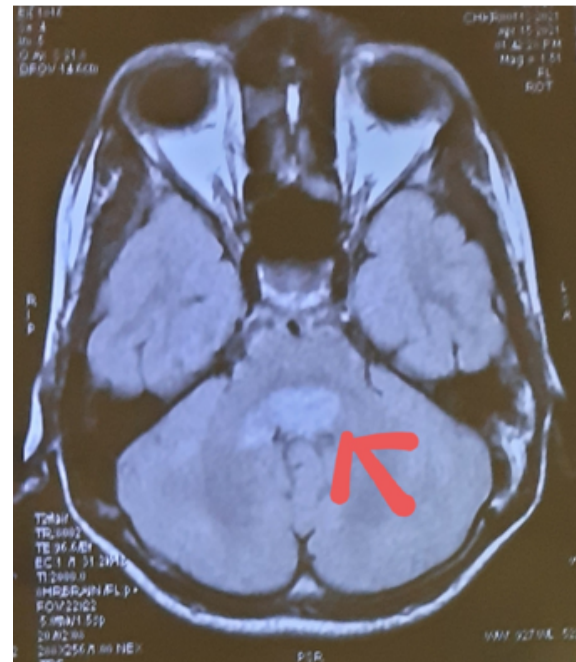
T2/FLAIR hyperintensity in pons
